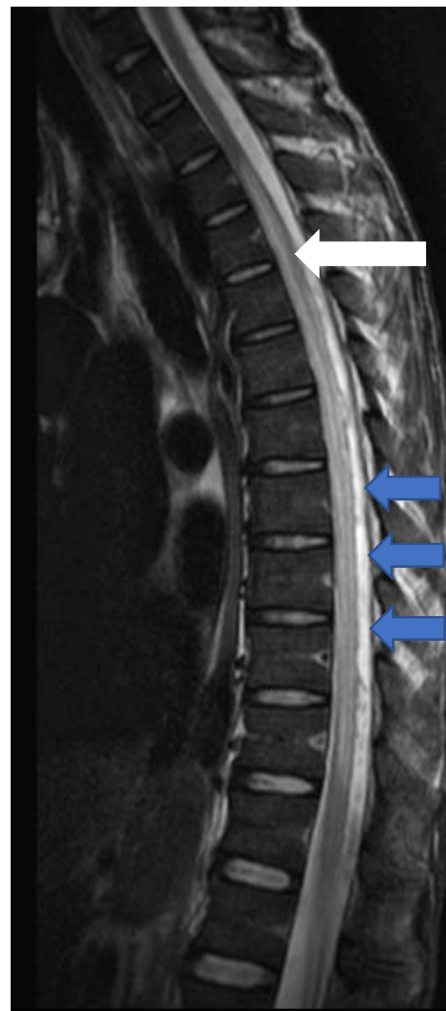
Initial MRI. White arrow shows a large area of abnormal hyperintensity in the thoracic spinal cord that extends from T3 level to T11 level. Smaller blue arrows point at the fluid collection posterior to the spinal cord suggestive of an abscess. This collection showed contrast enhancement on the post contrast images (not shown). MRI: magnetic resonance imaging
